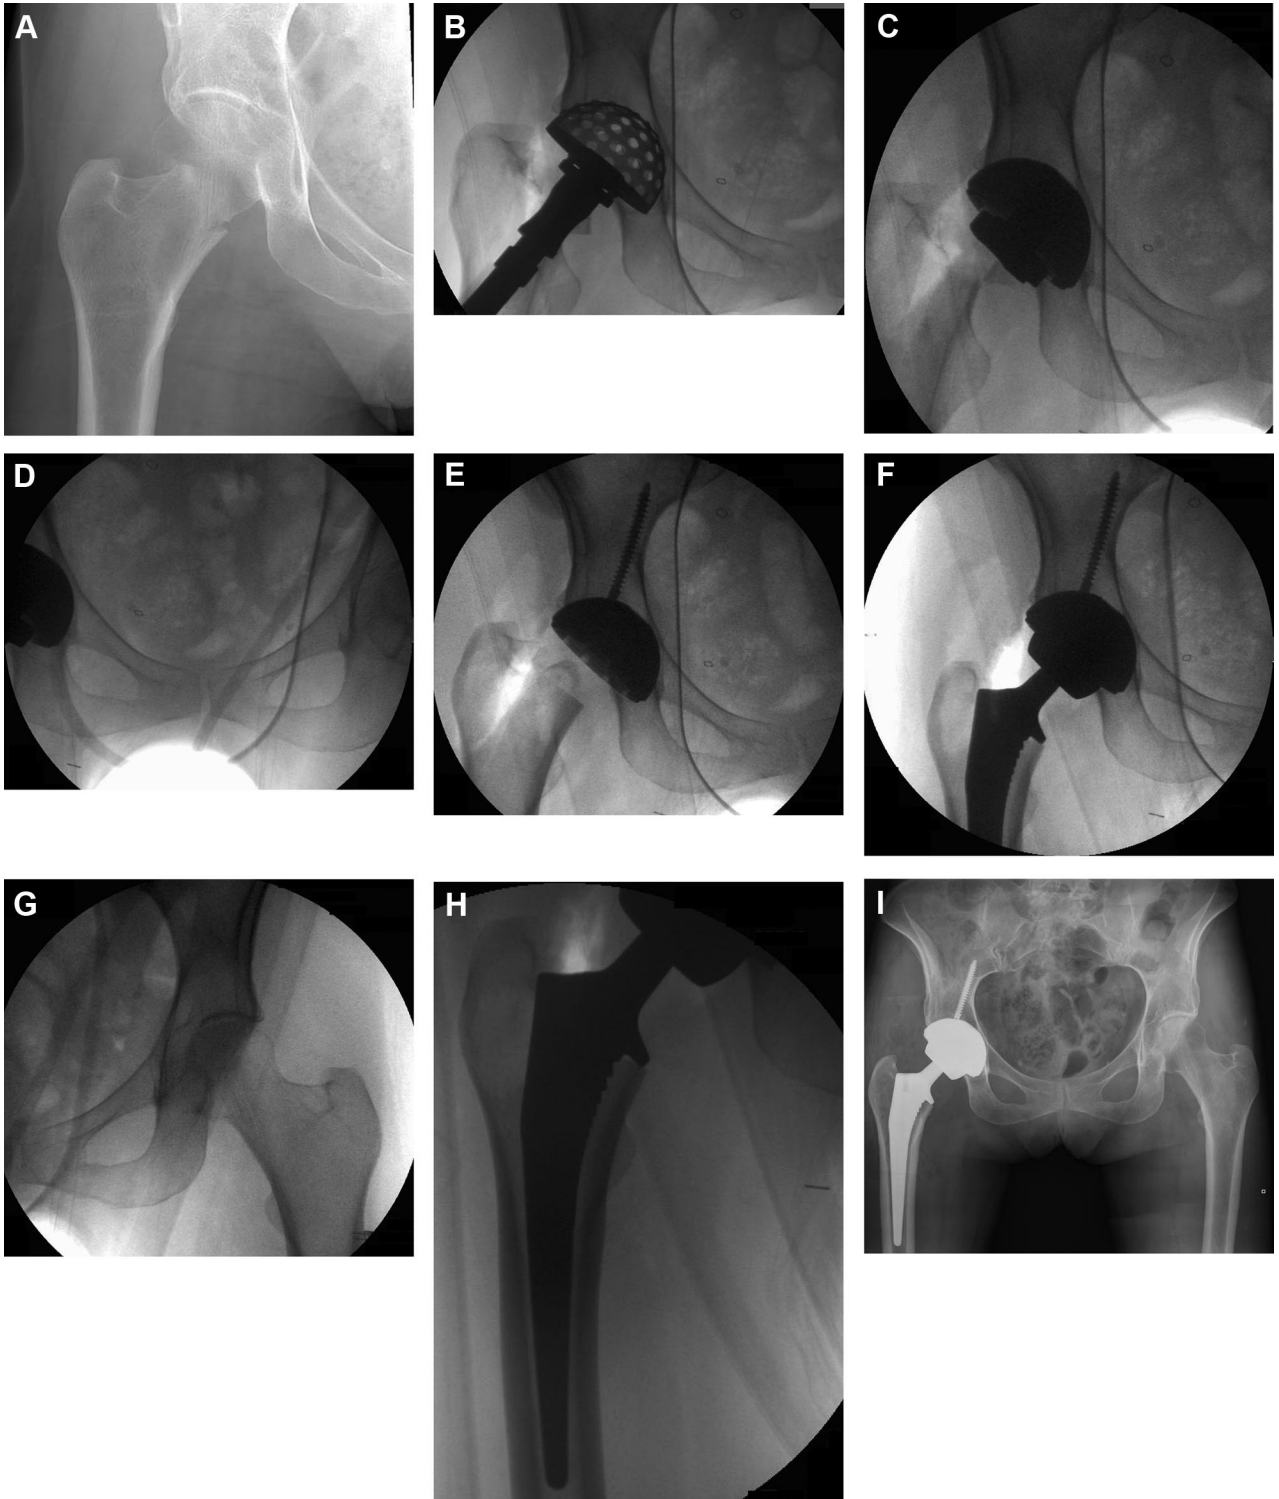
Case example of a 62-year-old female with moderate osteoporosis who sustained a right femoral neck fracture and a low energy fall. She has a type I diabetes mellitus. A, Anteroposterior (AP) hip radiograph demonstrating a displaced femoral neck fracture. After careful consideration and discussion with the patient and family, and taking into account her high functional activity, it was elected to perform a right total hip arthroplasty (as opposed to a hemiarthroplasty). B, Intraoperative x-ray demonstrating visualization of the reaming process. While this does not need to be done under fluoroscopic visualization, it is possible. C, Direct visualization of the cup placement. D, It is important for the surgeon to ensure that a proper
